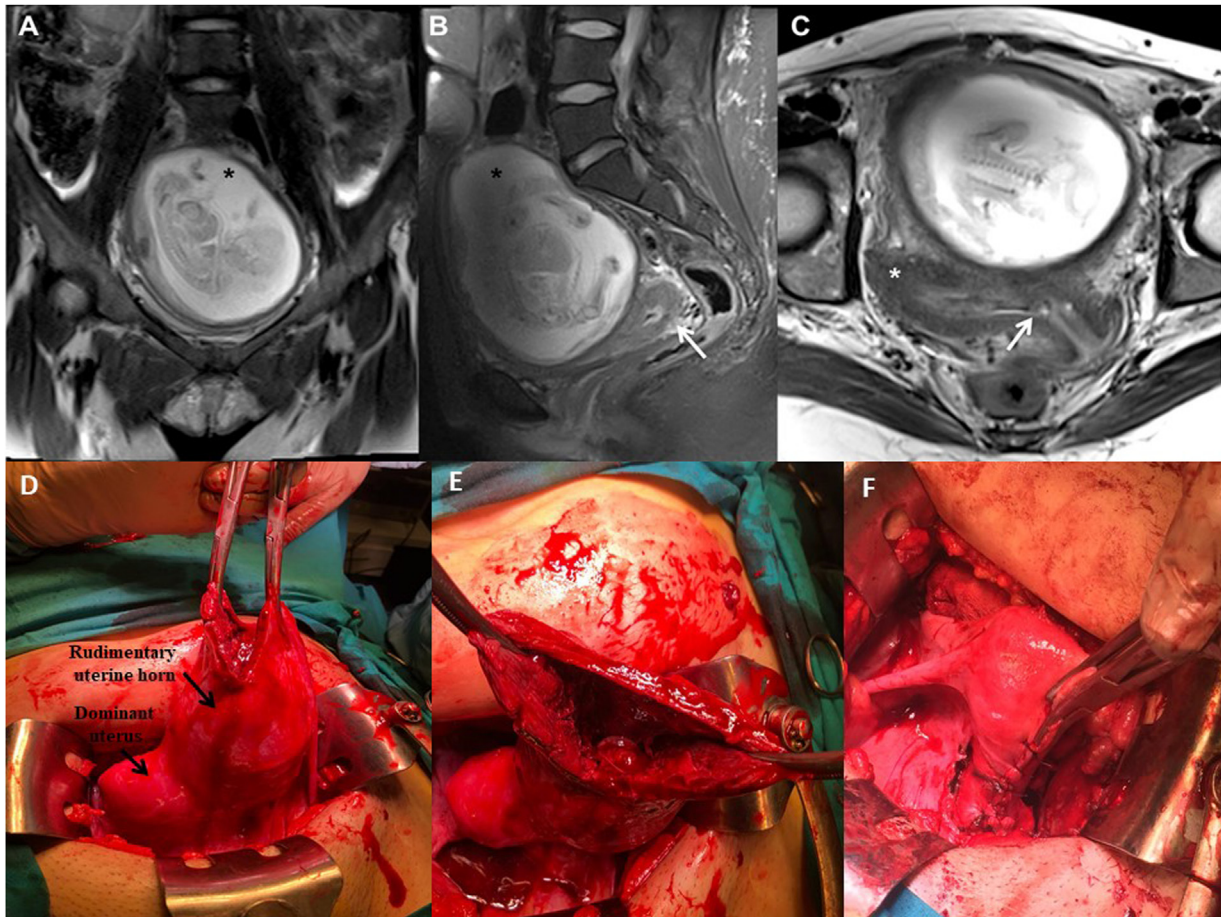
A–C. Coronal TSE T2-weighted (A), sagittal TSE T2-weighted with fat suppression (B). On the axial TSE T2-weighted (C) images. A rudimentary horn containing a 20-weeks dead fetus is detectable (black asterisks in A and B); the dominant uterus is posteriorly located (white arrow in B). On axial plane (C), a clear communication with the cervical canal (white arrow) is detectable only for the dominant uterus (white asterisk). D. The rudimentary uterine horn with pregnancy inside. E. Top view of rudimentary uterine horn without pregnancy. F. The dominant uterus after the removal of rudimentary uterine horn and the suture of the left side-wall.
